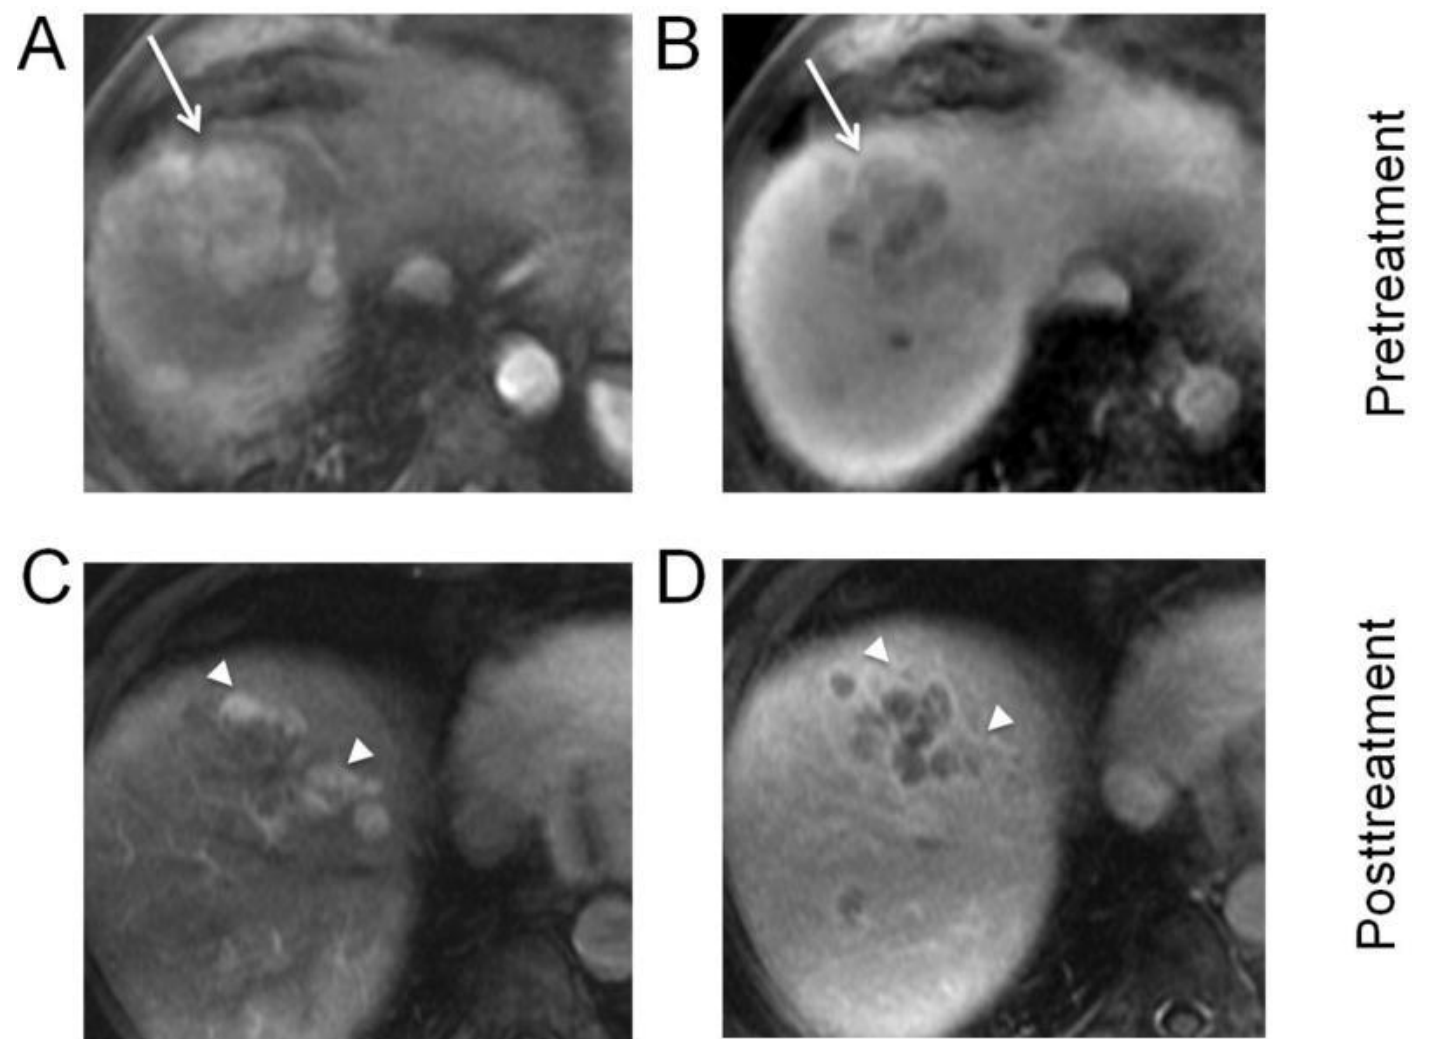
Imaging characteristics on MRI – (A) –Pre-TACE hyperenhancement. (B) – washout. (C) – Post-TACE hyperenhancement. (D) - washout⁴
